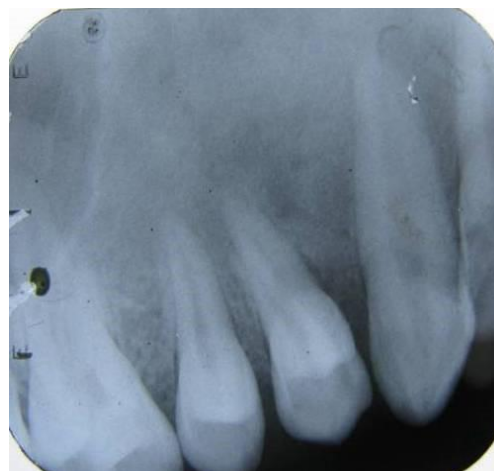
Intraoral periapical view
